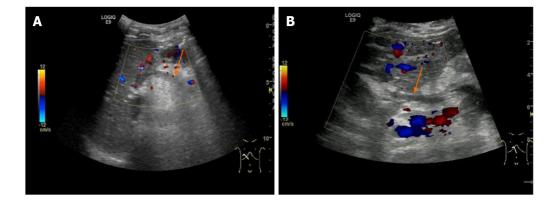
Color Doppler ultrasonography of a 13-year-old boy after recanalized umbilical vein as a conduit for Rex shunt (splenic veinumbilical vein shunt) operation. The boy was admitted to the hospital with hematemesis and black stool. A: Color Doppler flow imaging showed no blood flow signal in the bypass vessel (splenic vein) 7 d after operation; B: Color Doppler flow imaging showed no blood flow signal in the bypass vessel after clinical anticoagulation treatment for 3 mo. Arrow indicates splenic vein.
